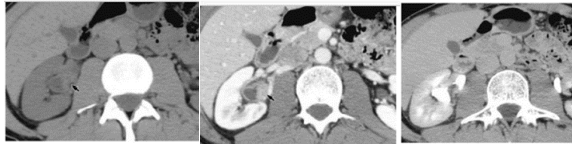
(left) axial non-enhanced CT-scan shows slightly hyperdense; (middle) axial nephrography shows an early enhancement of tumor and extension into situation of upper pole parenchym (arrow); (right) Axial excretory phase CT shows a mass within renal pelvis with surrounding excreted contrast medium.¹⁴
